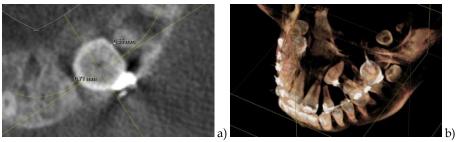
Follow-up (10 months) CBCT exam: a) axial view showing the close proximity of the crown of 2.3 to the apex of the root of 2.2 and 2.4; b) 3D image reconstruction
